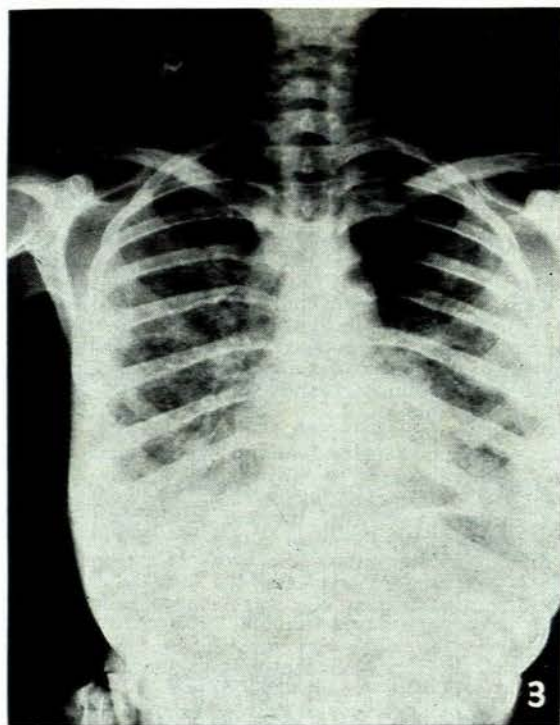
Diffuse ground-glass appearance of both lung fields. X-ray of chest 3 weeks before lung biopsy — case 4.
